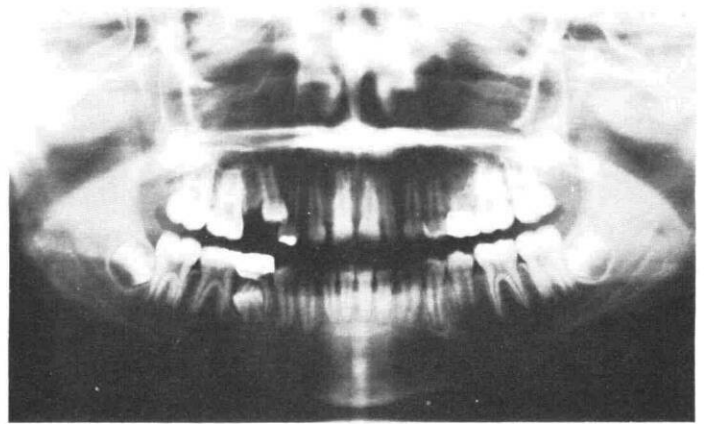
Panoramic radiograph at 11 years, 11 months.
